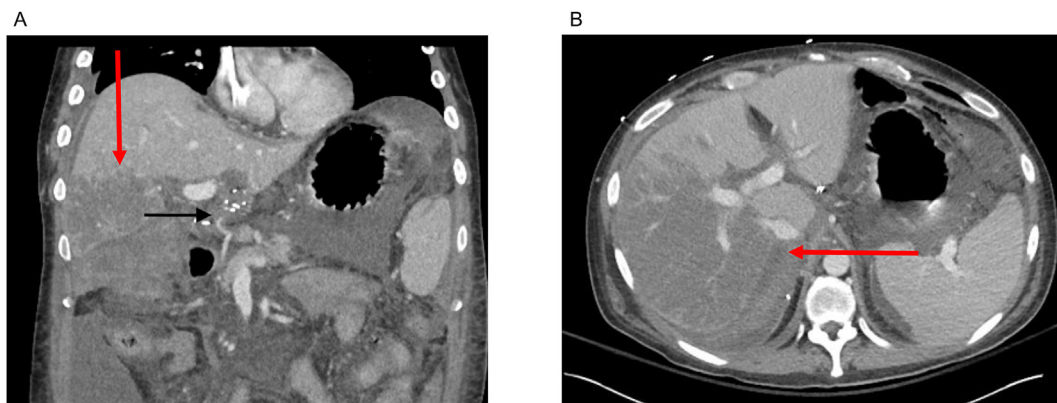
(A) Coronal reformat image of a computed tomography (CT) angiography of the abdomen demonstrating hypoperfusion of the right posterior lobe of the liver (red arrow) and nonvisualization of distal branches of the hepatic arteries in the parenchyma (black arrow). (B) Axial image of a CT angiography of the abdomen demonstrating hypoperfusion of the right posterior lobe of the liver (red arrow) and nonvisualization of distal branches of the hepatic arteries in the parenchyma (black arrow). (For interpretation of the references to color in this figure legend, the reader is referred to the Web version of this article).
